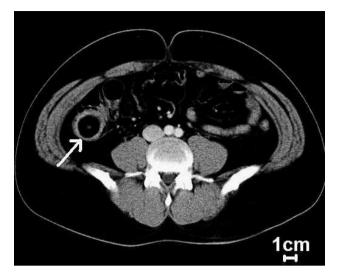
Abdominal CT showed a low-density mass and intussusception in the ascending colon (arrow).
